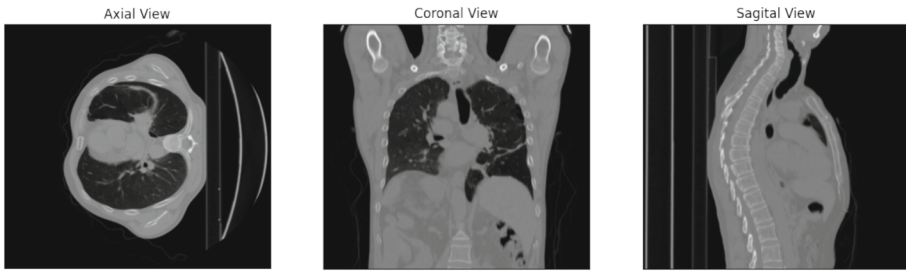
Examples of 2D images obtained from a CT scan.
